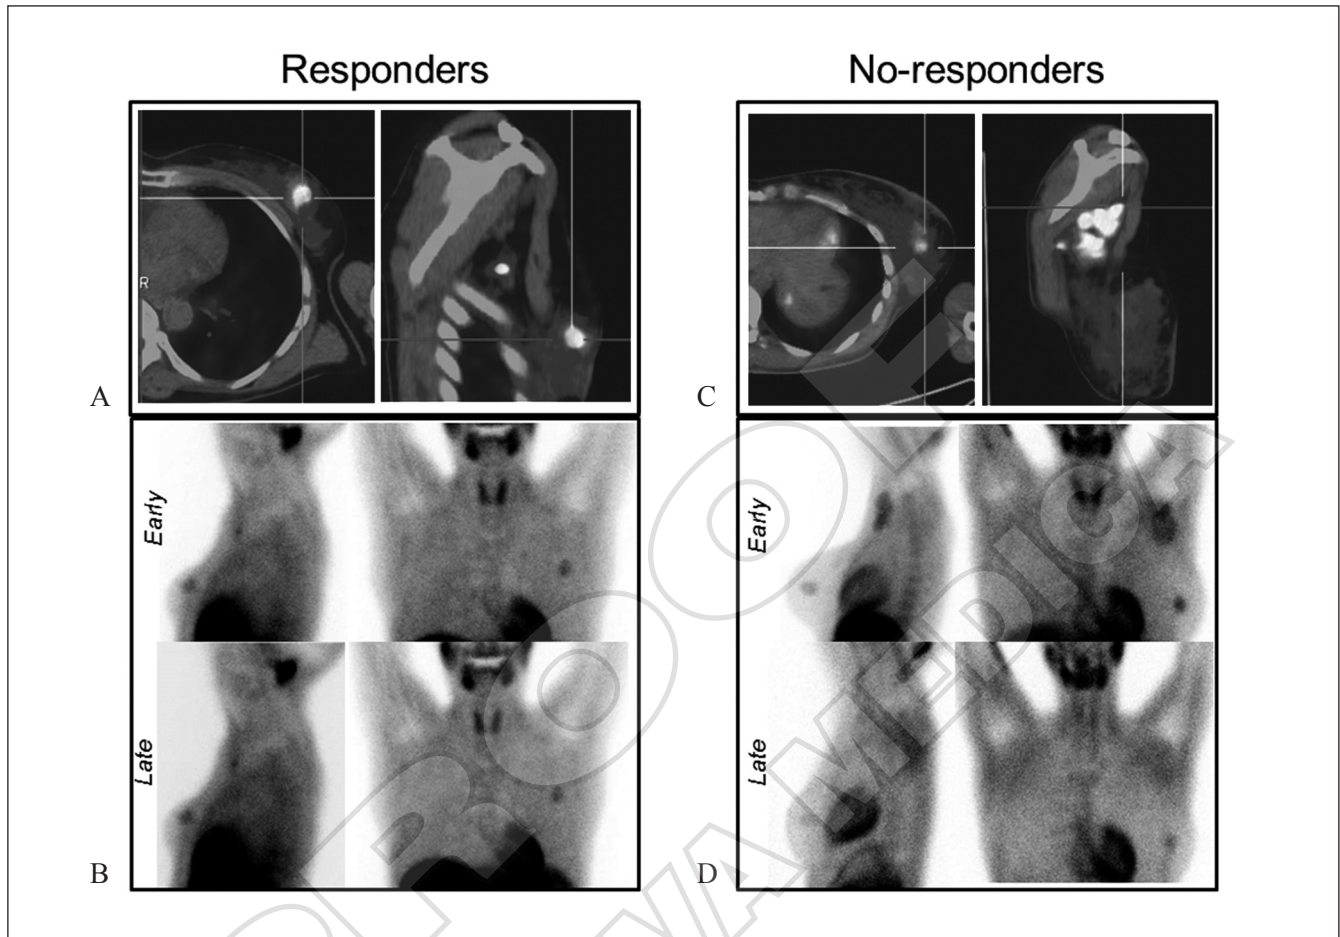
Images relative PET/CT and scintimammographic studies in responder (A, B) and non-responder (C, D) patients.
